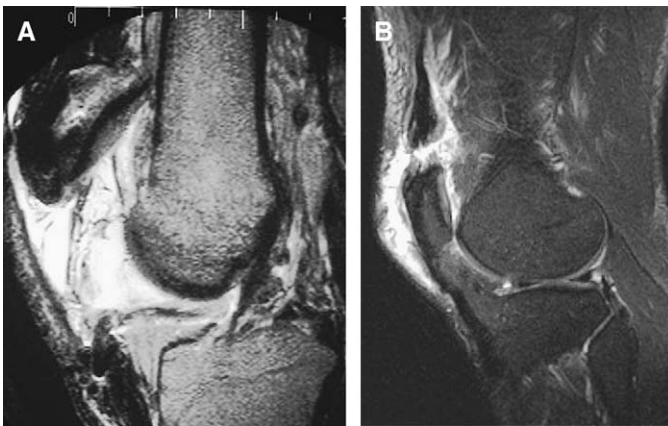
(A) Patellar tendon rupture. T2-weighted sequence shows patella alta with discontinuity of the patellar tendon and associated edema. (B) Quadriceps tendon rupture. T2-weighted fat-saturated sagittal image shows discontinuity of the quadriceps tendon with associated edema.
